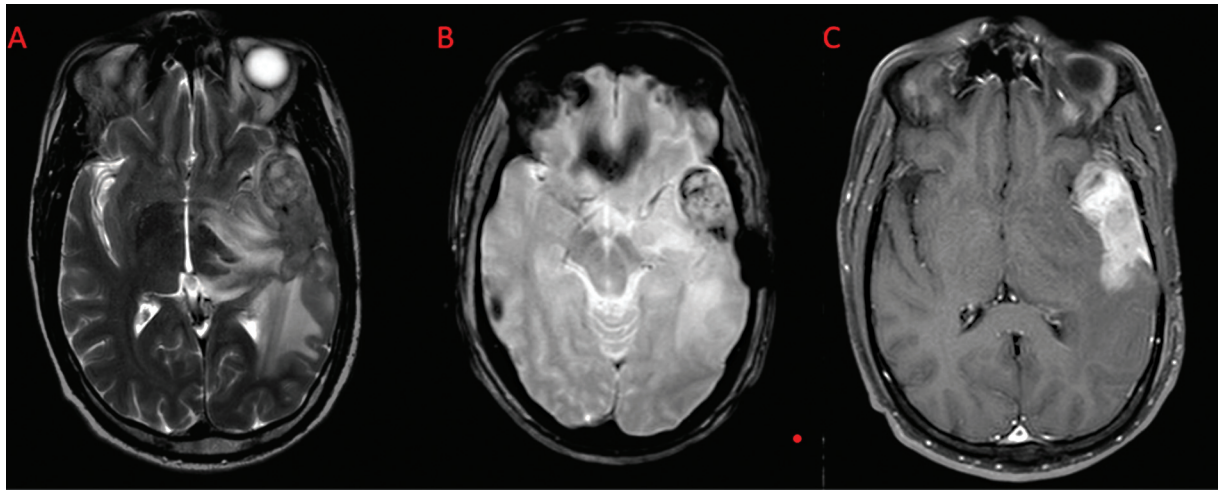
The tumor in left temporal lobe showing hyperintensity on T2-weighted image (T2WI) with edema (A). Intratumoral hemorrhage on gradient echo (GRE) (B) and enhancement on T1W (C).
